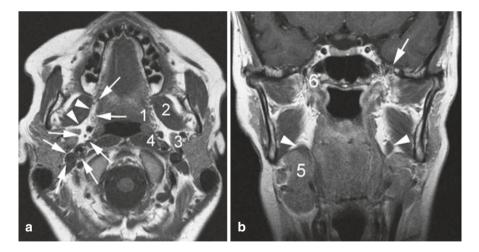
Axial T1-weighted spin-echo image (a) at the level of the soft palate. The boundaries of the parapharyngeal space (PPS) (including prestyloid and retrostyloid compartment) are indicated by *arrows* and *arrowheads* on the right. On the left, the adjacent spaces are labeled: 1, pharyngeal mucosal space; 2, masticator space; 3, parotid space; 4, retropharyngeal/prevertebral space. (b) Coronal T1-weighted spin-echo images through prestyloid compartment of the PPS. Inferiorly, this space is closed by the submandibular gland (5), while superiorly, it reaches the skull base (6). The foramen ovale (*arrow*), through which the mandibular nerve passes, communicates with the masticator space. The styloglossal muscles run through the PPS (*arrowheads*). From [1]
